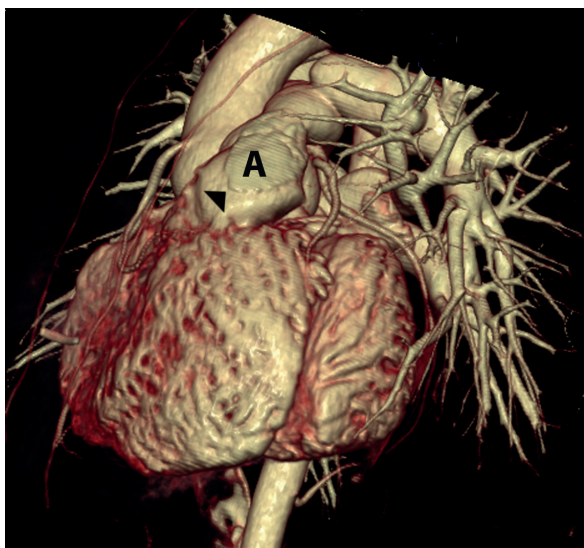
Stent on the right pulmonary artery visualized with cardiac CT.
